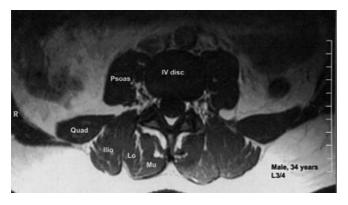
Magnetic resonance imaging (MRI) cross-section of the trunk muscles at L3/4, in a 34-year-old man (10-cm calibration rule on *right*). The iliocostalis lumborum, longissimus thoracis pars lumborum and multifidus muscles were combined to give a measure of the erector spinae size. (*IV Disc* intervertebral disc, *Quad* quadratus lumborum, *Ilio* iliocostalis lumborum, *Lo* longissimus thoracis pars lumborum, *Mu* multifidus)
